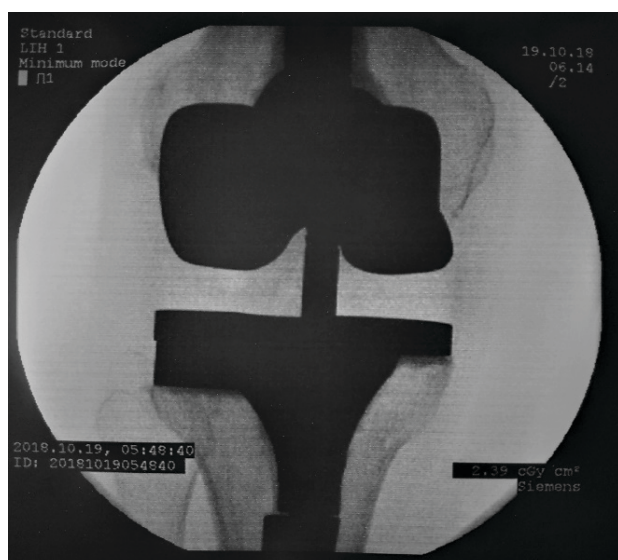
Postoperative right knee AP view X-ray. The TS prosthesis can be seen in place, with no detectable radiolucent lines
